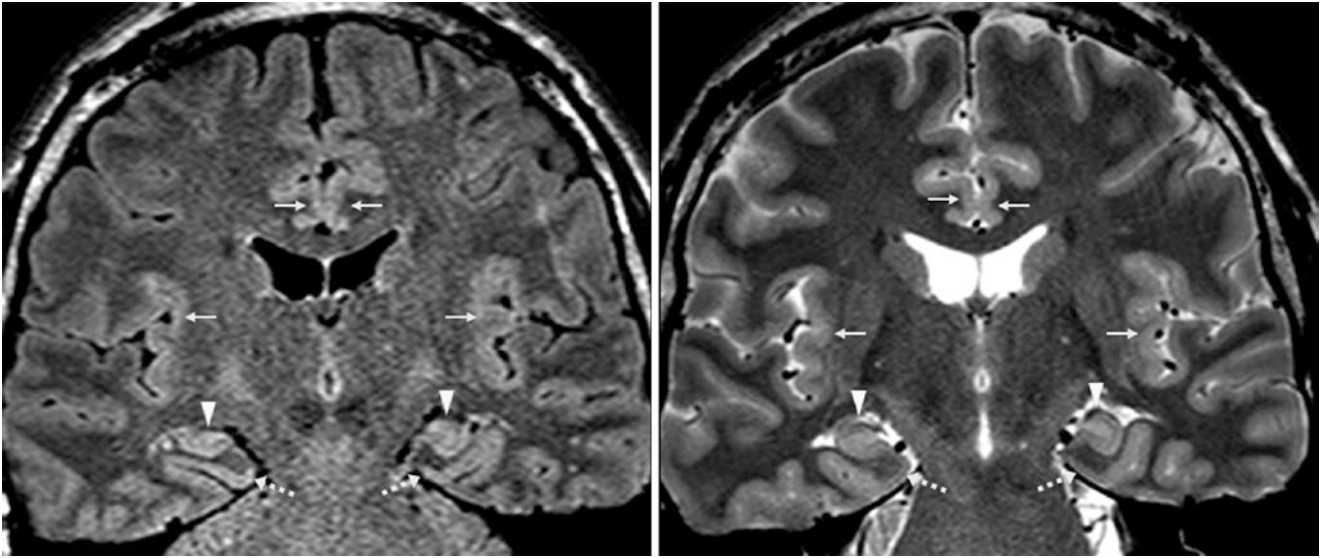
A 27-year-old with a first-time seizure had a 3 T MRI with coronal FLAIR (*left*) and T2WI (*right*), which showed mildly bright hippocampi (*arrowheads*) and cortices of the parahippocampal gyri
